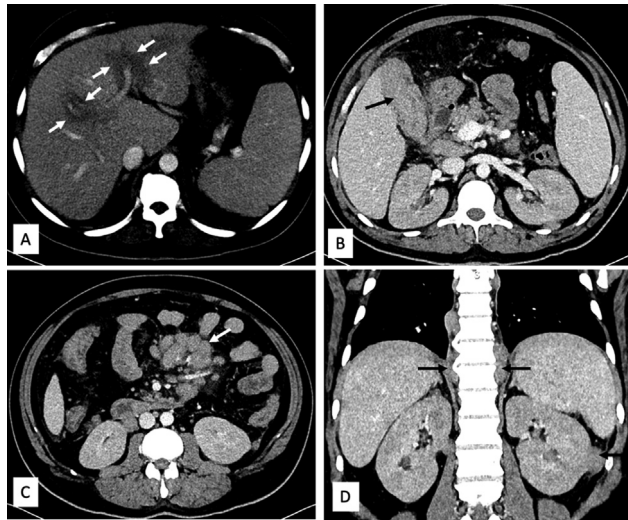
Axial contrast-enhanced computed tomography (CECT) image at the level of portal vein bifurcation (A) shows linear circumferential periportal hypodensity along the right and left portal vein branches (white arrows). Axial CECT image (B) shows extensive gallbladder mural thickening and pericaval lymph node. Axial CECT image (C) shows enlarged conglomerated mesenteric lymph node encasing the mesenteric vessels. Coronal CECT image (D) shows paravertebral and left perirenal enhancing soft tissue deposits.
